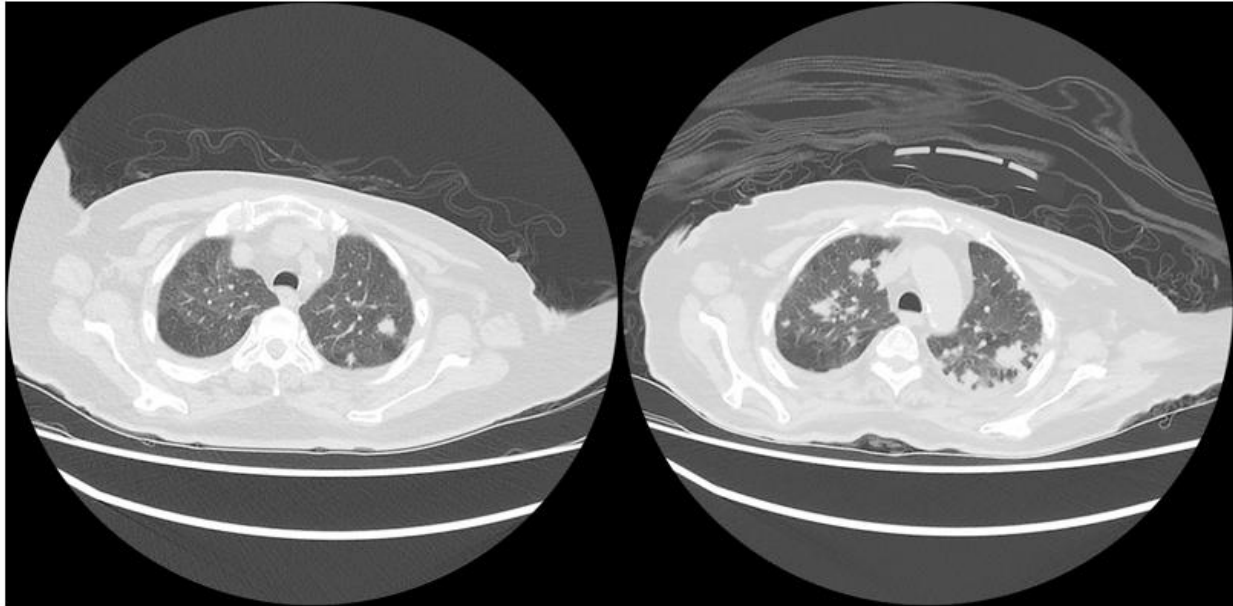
Computed Tomography (CT) Chest images on presentation
